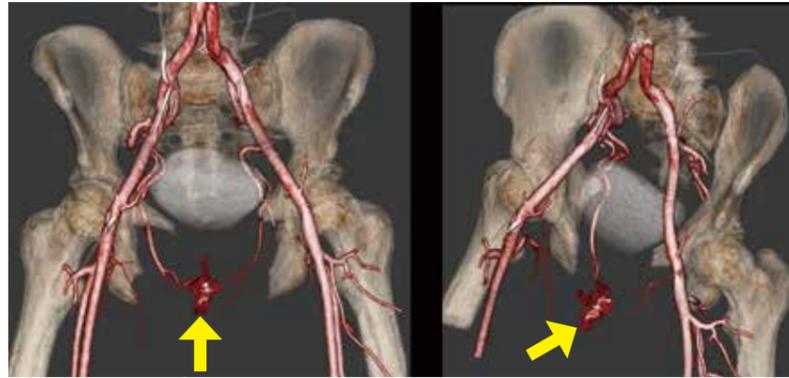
CT of Aortic bifurcation. 3D Volume rendered AP and Oblique views
